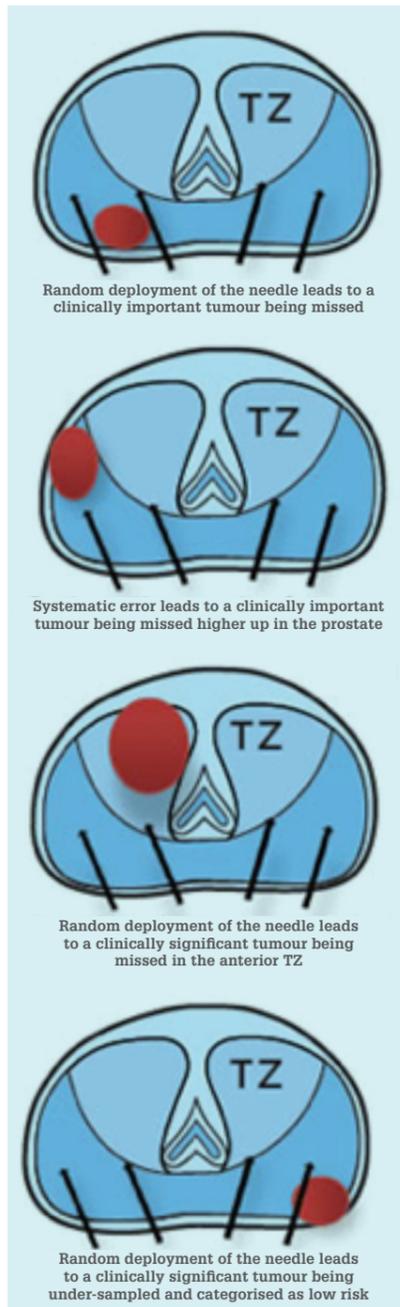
Sampling errors from standard trans-rectal ultrasound guided prostate biopsies
